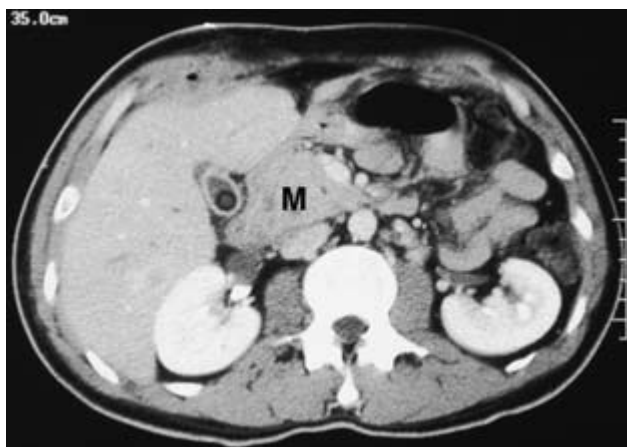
Triple phase spiral CT scan showing mass (M) in head of pancreas due to carcinoma. There is involvement of the superior mesenteric vein medially, and the lesion was irresectable.
